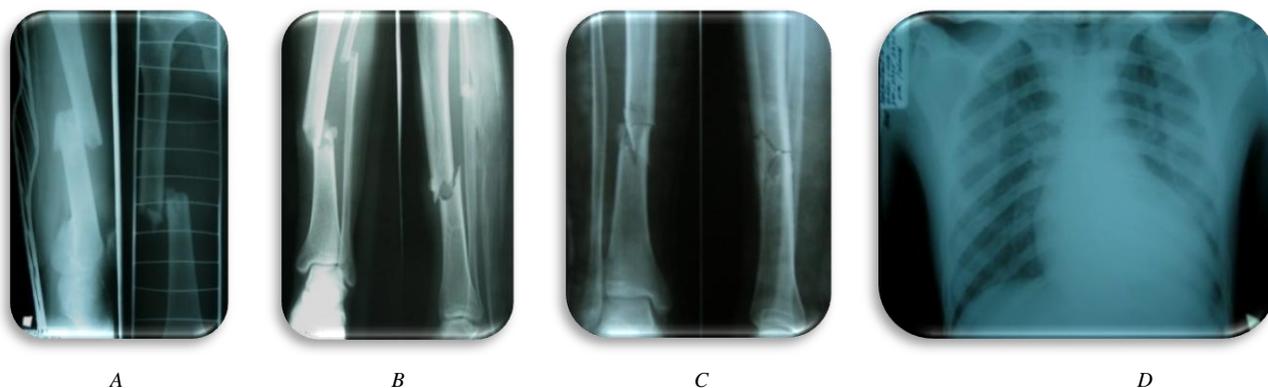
Chest and extremities X-ray: A- Fracture of the middle third of the right femur with a displacement of bone fragments. Type B; B and C-comminuted fractures of the middle third of tibia and fibula with the displacement of bone fragments. Type B; D - Plain X-ray of chest without bone-traumatic changes
